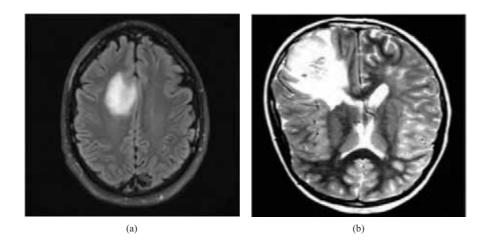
MRI Image after implementing EPCMA+ML-ELM
